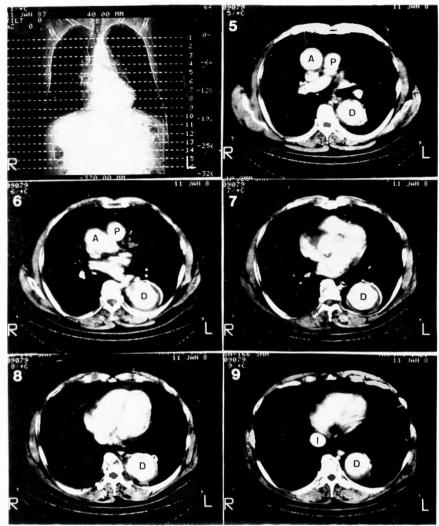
Preoperative CT scan showing arteriosclerotic dilatation of the descending aorta Λ: ascending aorta, P: pulmonary artery, D: descending aorta, I· inferior vena cava, No.. slice No
